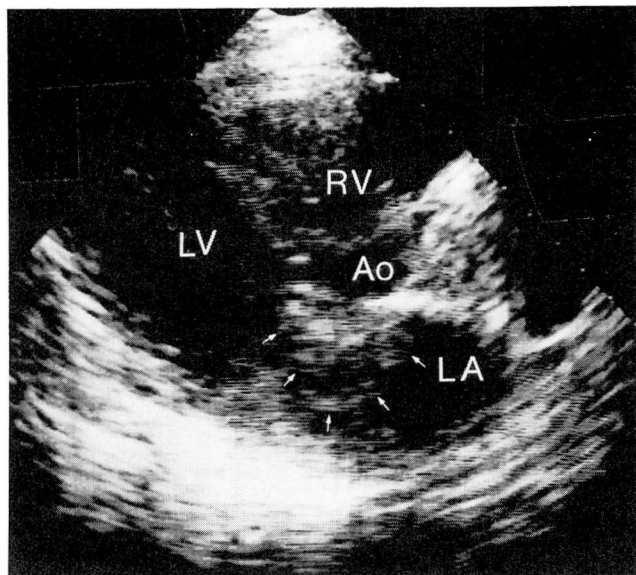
Two-dimensional echocardiogram, long axis parasternal view. A mass (outlined by arrows) arises from the lower portion of the atrial septum and extends into the left atrium and onto the anterior mitral leaflet.
